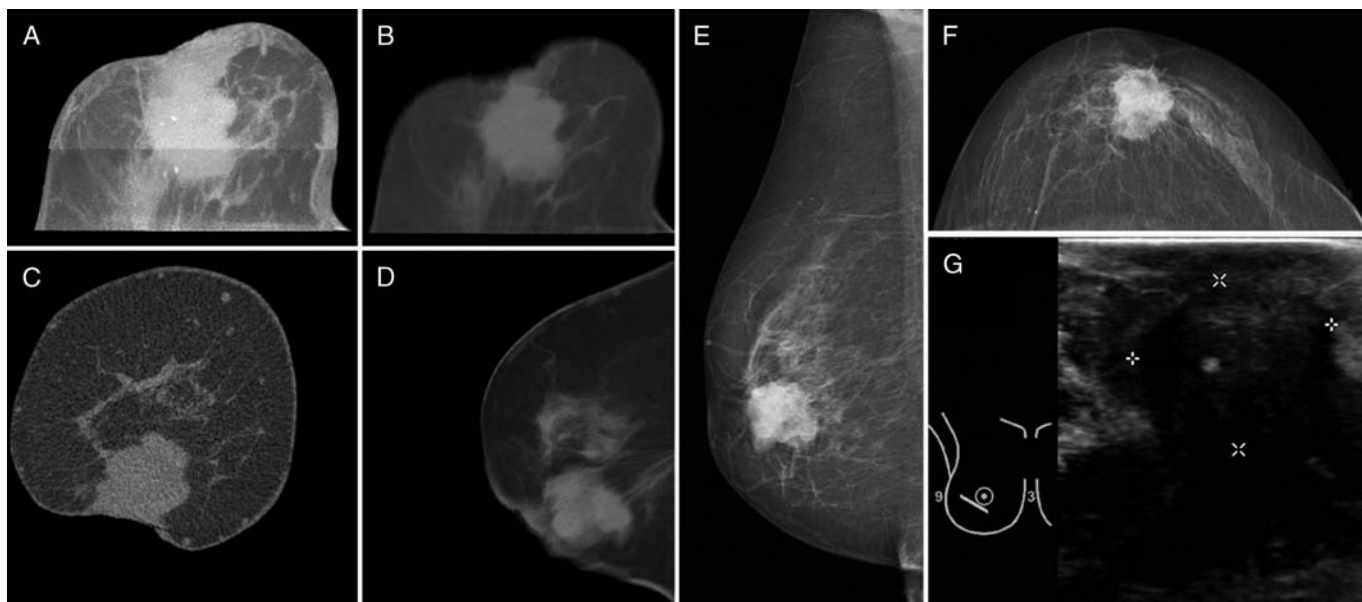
A symptomatic 64-year-old patient with no previous examination of the breast and a palpable lump in the right breast. The patient refused mammography. An ultrasound-guided core biopsy was performed, diagnosing an invasive ductal carcinoma. A, B-CT with axial MIP (10 mm) with retro-areolar mass and involvement of the nipple with associated microcalcifications and macrocalcifications. B, B-CT with axial avgIP (10 mm) showing the same mass. The architectural distortion can be better depicted as in the MIP. C, B-CT with coronar reconstruction (150 µm). D, B-CT with sagittal avgIP (10 mm) reconstruction. E, Corresponding mammography in MLO projection showing the mass. F, Corresponding mammography in CC projection showing the mass. G, Ultrasound showing an ill-defined, hypoechoic mass with calcifications and a dorsal signal loss.
